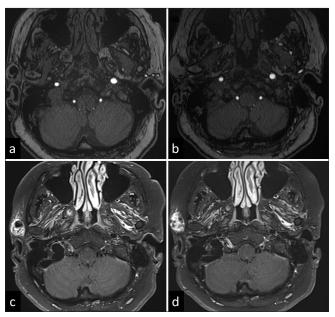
(a and c) Follow-up magnetic resonance images at 1 and (b and d) 4 months after surgery showed (a and b) no blood flow signal at the embolization site, but (c and d) enhanced thrombosed area was increased. The size of the aneurysm increased from (c) 15.25 mm to (d) 16.11 mm.
